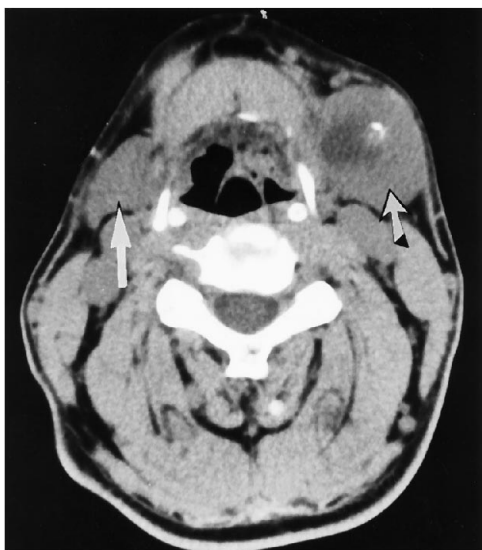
CT without contrast demonstrates the enlarged left submandibular gland with a density lower than that of the normal side (*straight arrow*) and a marginal calcification (*slanted arrow*). The interface between the lesion and the normal salivary gland tissue was indistinct.
